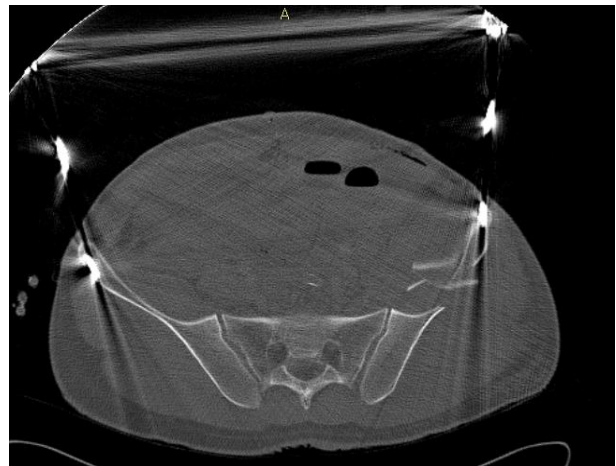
Pelvic CT, axial image, showing the external fixator of the pelvic fracture.
